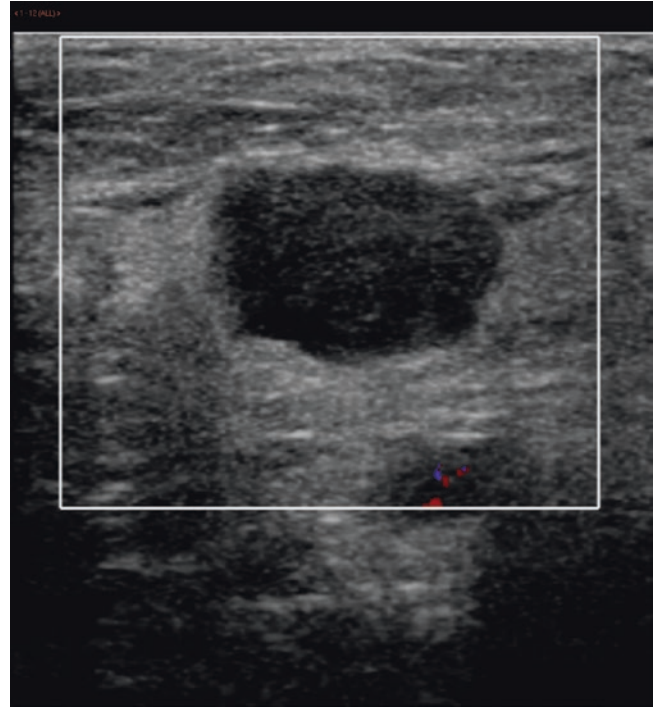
Complete thrombosis of the pseudoaneurysm sac following ultrasound guided thrombin injection. No further treatment was required
